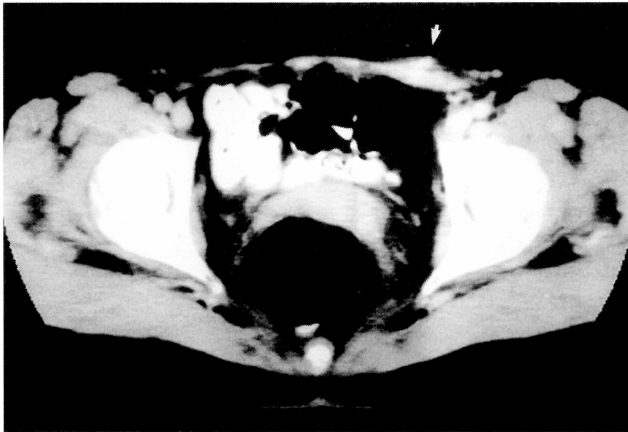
Case No. 2: Abdomino-pelvic CT scan performed six days following initial laparoscopy, with IV injection of contrast medium. Left oblique muscle was thickened (arrow) due to the recent laparoscopy without nodular lesion.
